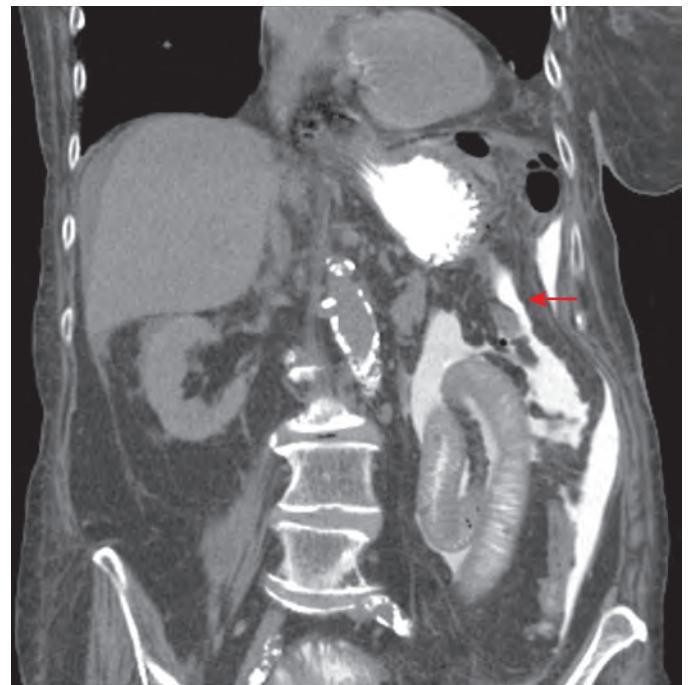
Perforated gastric ulcer: CT findings. Extravasated contrast material (arrow) is present in peritoneal spaces of the left upper quadrant.
